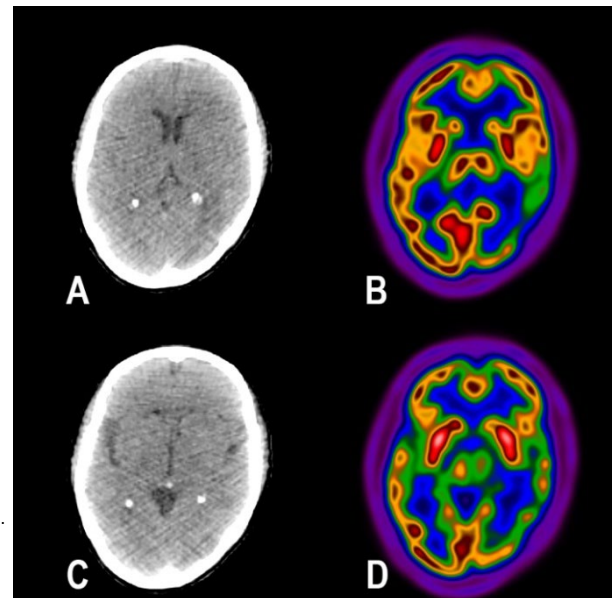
FDG PET/CT revealed decreased metabolic activity in the left temporoparietal lobe of the brain.
